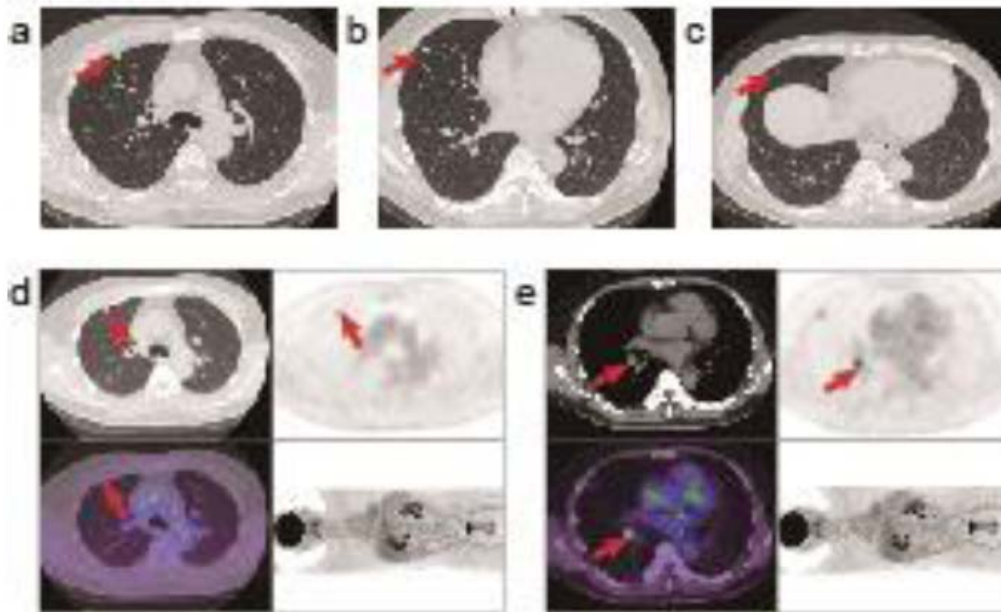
Imageological findings of new on-set lung lesions of patient 2 about 7 weeks before diagnosis as lung NET. a-b. Solid nodules in the right upper lung with a maximal size of 0.6 cm in diameter. c. Solid nodule in the right middle lung. d. Slightly increased glucose metabolism (SUVmax 1.6) in the lung lesion in the right upper lung. e. Slightly increased metabolism (SUVmax 3.9, maximum diameter 0.5 cm) in lymph nodes in right hilar and mediastinum.
